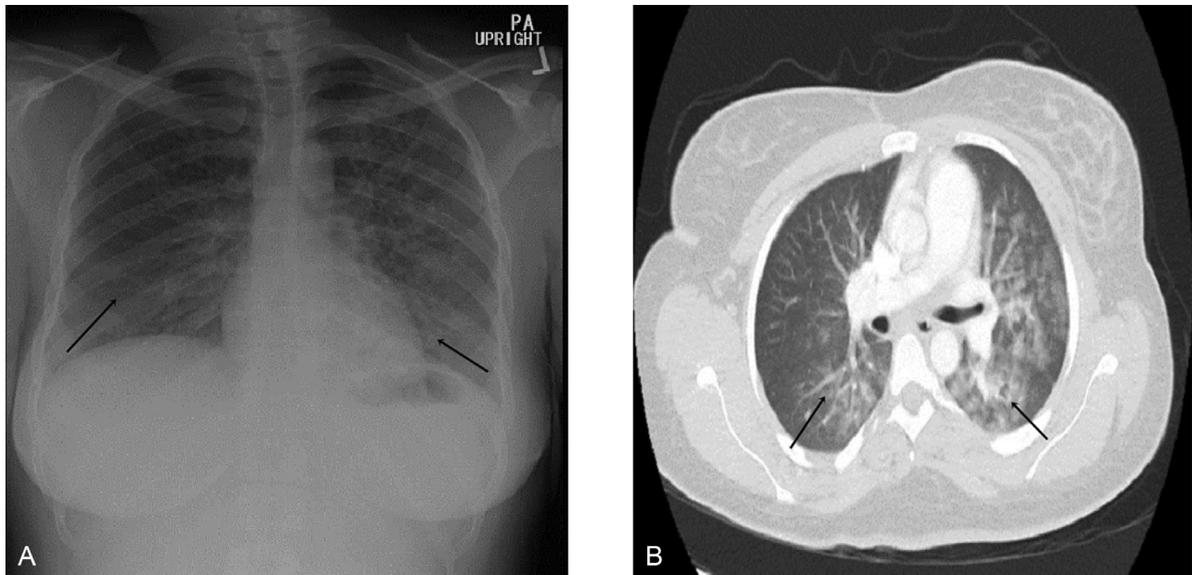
(A) Chest X-Ray showing multifocal airspace opacities throughout the left lung and in the right upper lung concerning for multifocal pneumonia. (B) Computed Tomography scan of the chest in axial plane showing lesions concerning for multifocal pneumonia but no pulmonary embolus.
